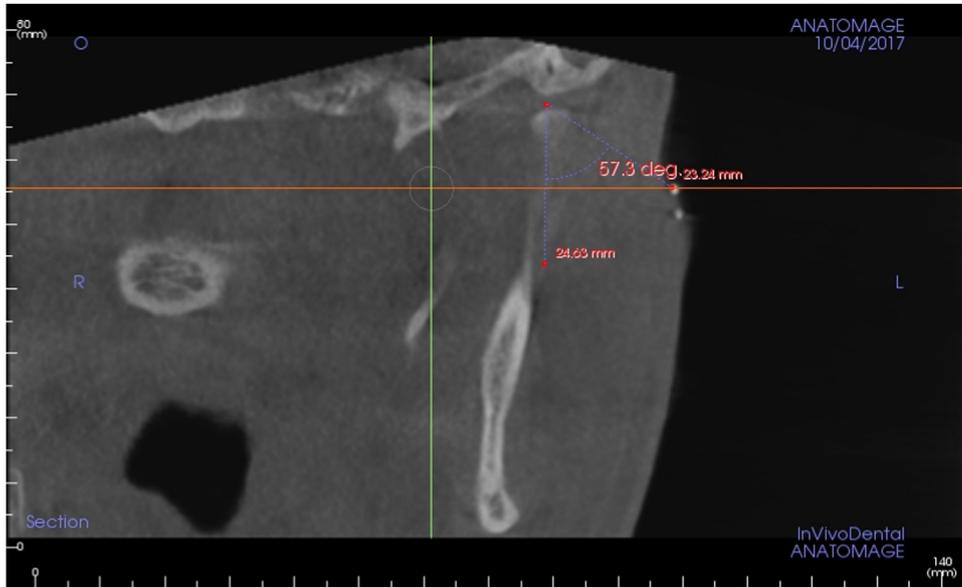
Coronal cone-beam computed tomogram showing the Guarda-Nardini insertion point and the measured correct insertion point cranial to it. The angle of insertion of the needle is 32.7° (calculated as 57.3° measured on the coronal plane - the vertical line is deducted from 90°), which would be the perpendicular line to the skin. The usual angle of insertion measured was between 30° and 35°.
